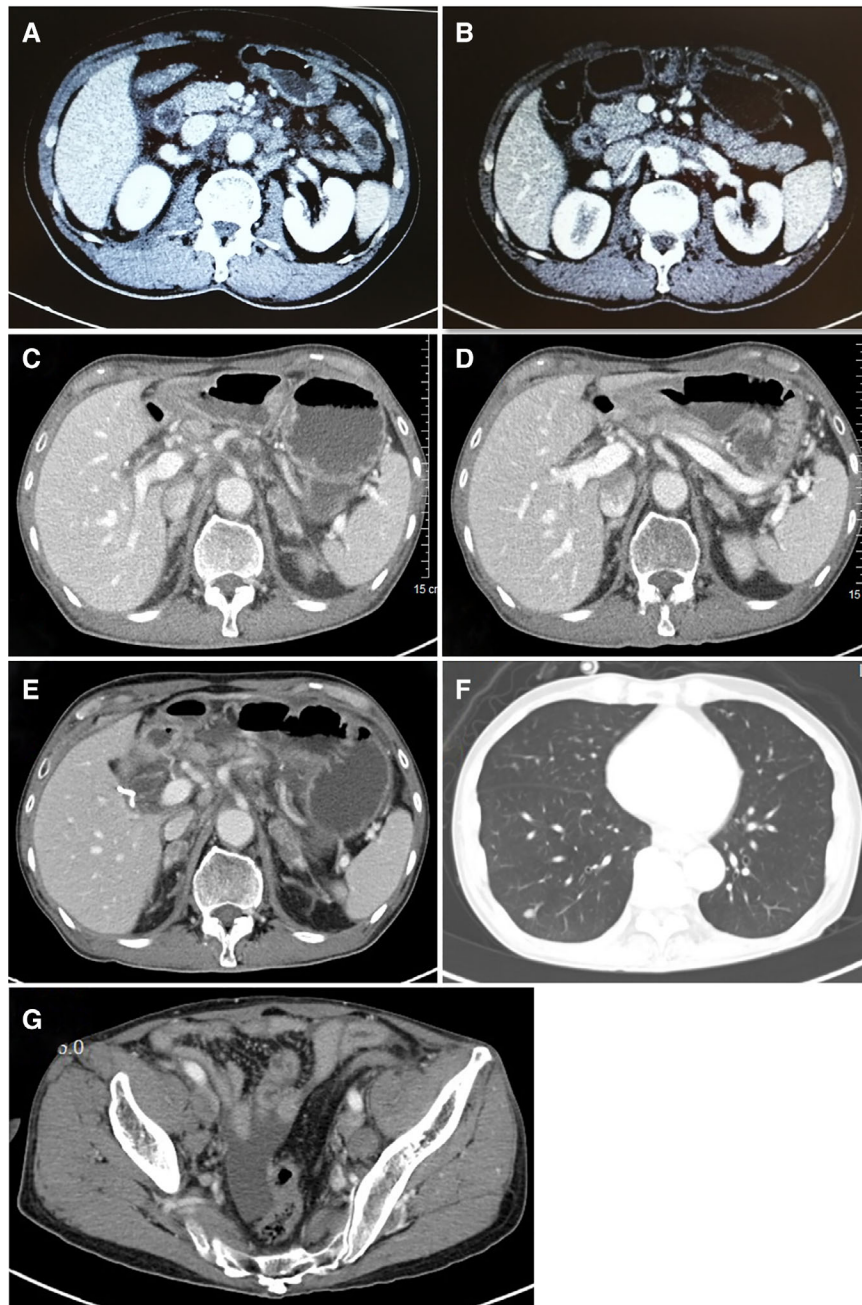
Positron emission tomography/computed tomography scans. (A): Multiple lymph node metastases before drug treatment. (B): Enlarged lymph nodes in abdominal aorta and root of the mesentery after treatment with XELOX regimen. (C): Enlarged lymph nodes in the retroperitoneum and bilateral adrenal metastasis before erlotinib treatment. (D): Reduction of para-aortic lymph nodes and bilateral adrenal metastasis after treatment with erlotinib for 20 days. Enlarged lymph nodes in the retroperitoneum and bilateral adrenal metastasis (E), enlarged metastatic tumor in right lower lung (F), and new metastatic lymph nodes on both sides of the pelvic cavity (G) after treatment with erlotinib for 82 days.
